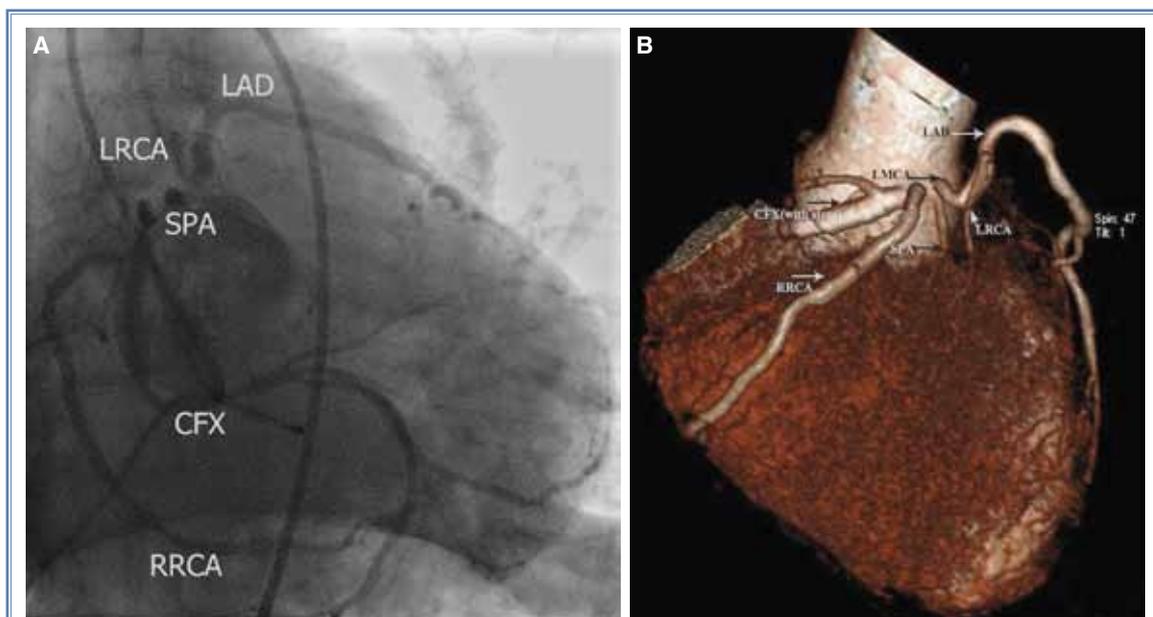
(A) Aortography showing all coronary arteries arising from the right coronary sinus. (B) Cardiac computed tomography showing origins of all coronary arteries and their courses.
